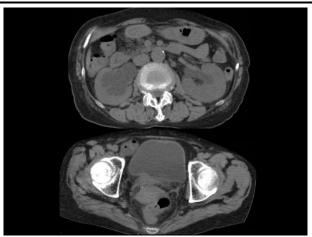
Computed tomography (CT) findings at the referring hospital.
